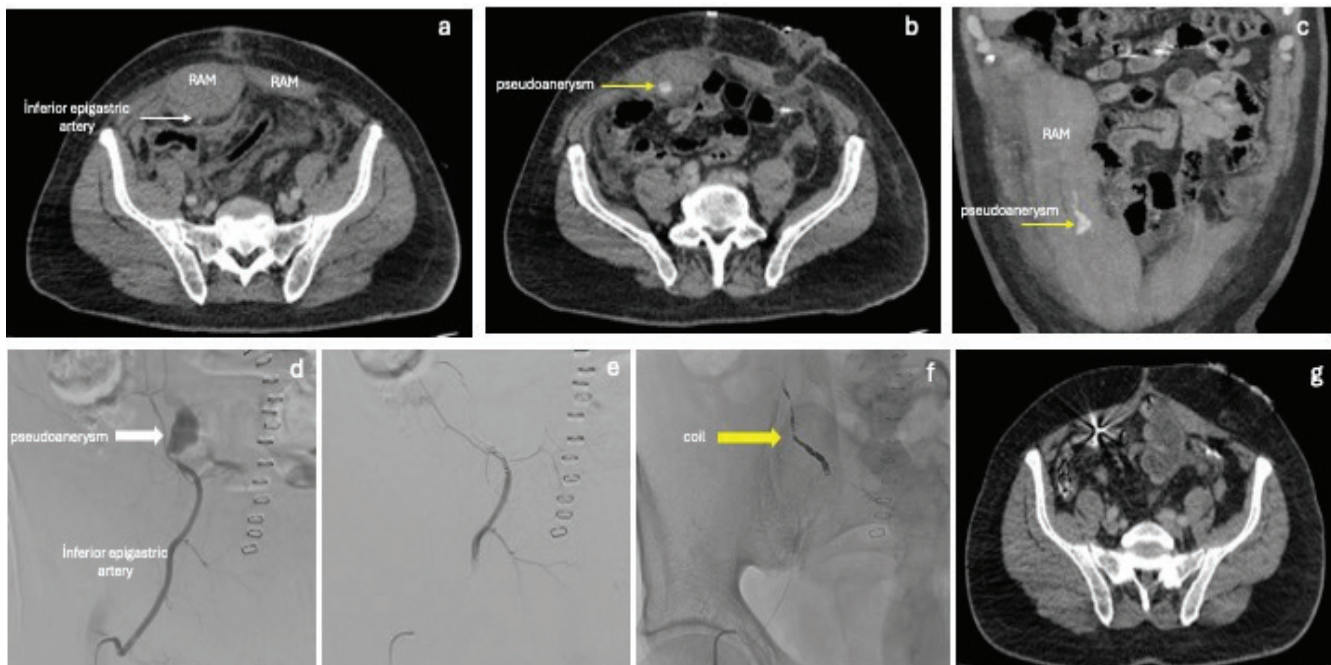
A 65-year-old male patient who developed right-sided RSH after surgery for colorectal cancer. (a, b) Axial and (c) coronal CT angiography images demonstrating the inferior epigastric artery (thin white arrow), a pseudoaneurysm (thin yellow arrows), and the presence of RSH, (d) selective angiography of the inferior epigastric artery, showing pseudoaneurysm filling (thick white arrow), (e) post-embolization DSA, confirming successful coil embolization with no residual pseudoaneurysm filling, (f) non-subtracted fluoroscopic image, displaying embolization coils (thick yellow arrow), (g) follow-up contrast-enhanced CT one week after the procedure, showing metallic artifact from the coils and resolution of the hematoma
